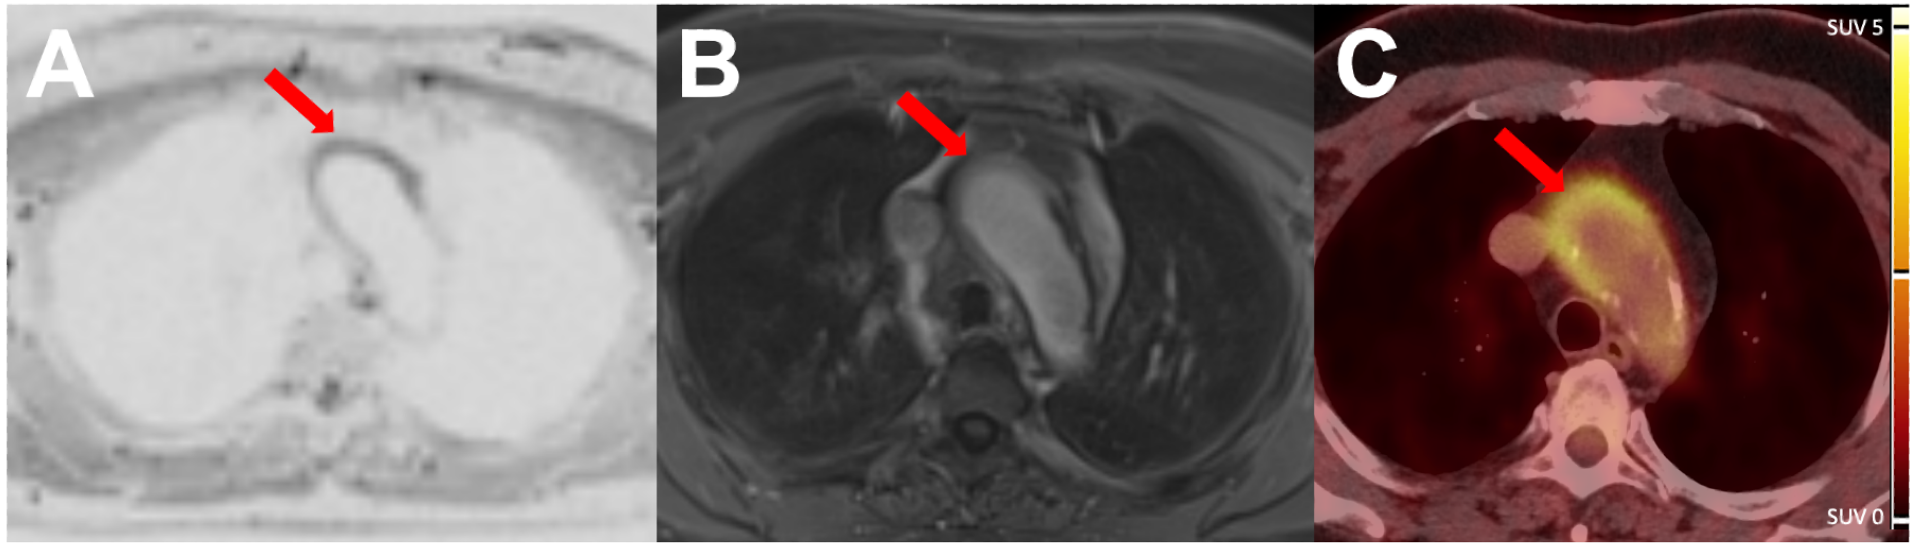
Imaging examples of a patient who remained in remission despite vasculitic findings in the thoracic aorta on MRI and PET/CT: MRI shows vessel wall oedema on low b-value diffusion weighted sequences (A) and vessel wall thickening and enhancement on T1w post Gadolinium (B). PET/CT shows increased FDG uptake in the aortic arch (C). Red arrows highlight vessel wall oedema, contrast enhancement and increased FDG uptake, respectively.
